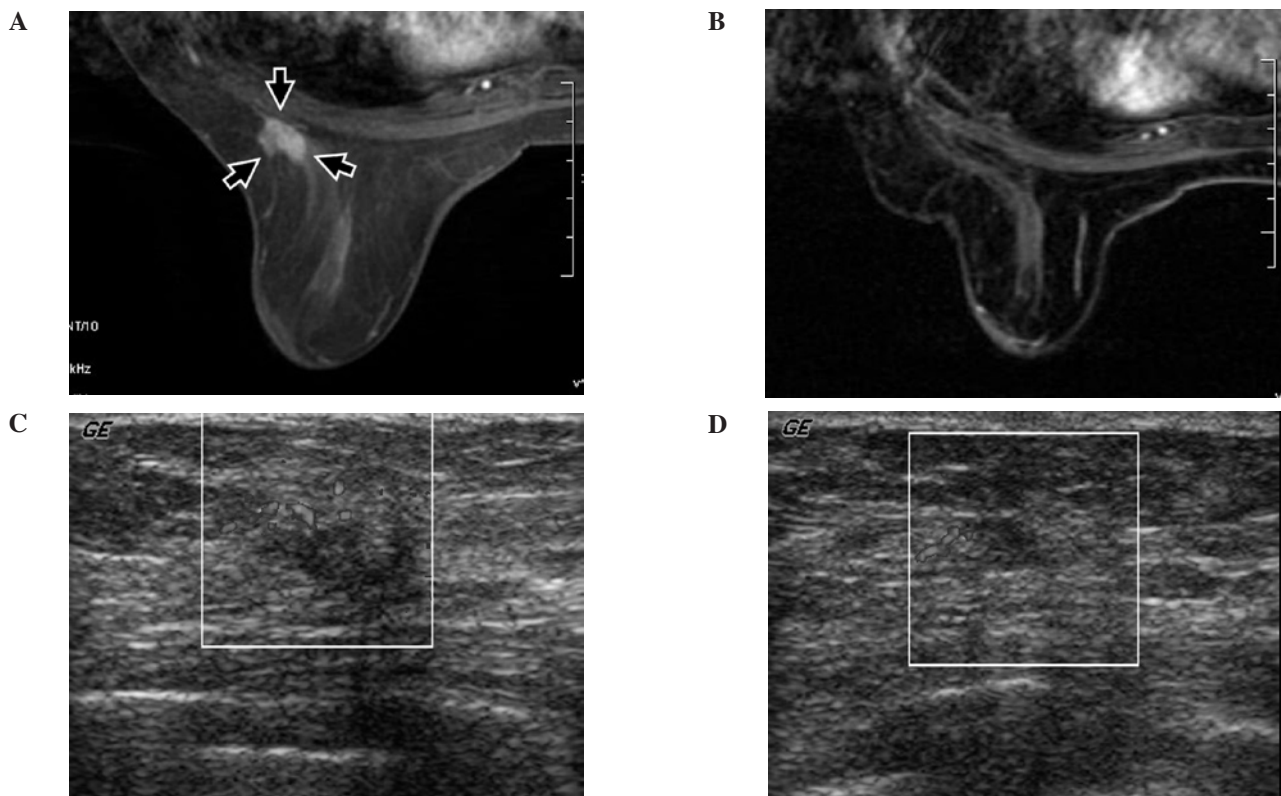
A 74-year-old woman with left breast invasive ductal carcinoma (case 6 in Table I). CE-breast MRI before therapy (A) revealed tumor enhancement (arrows). CE-breast MRI immediately after therapy (B) verified complete response of the lesion. US of the lesion before therapy (C) compared to immediately after therapy (D) also showed complete response of the lesion.
